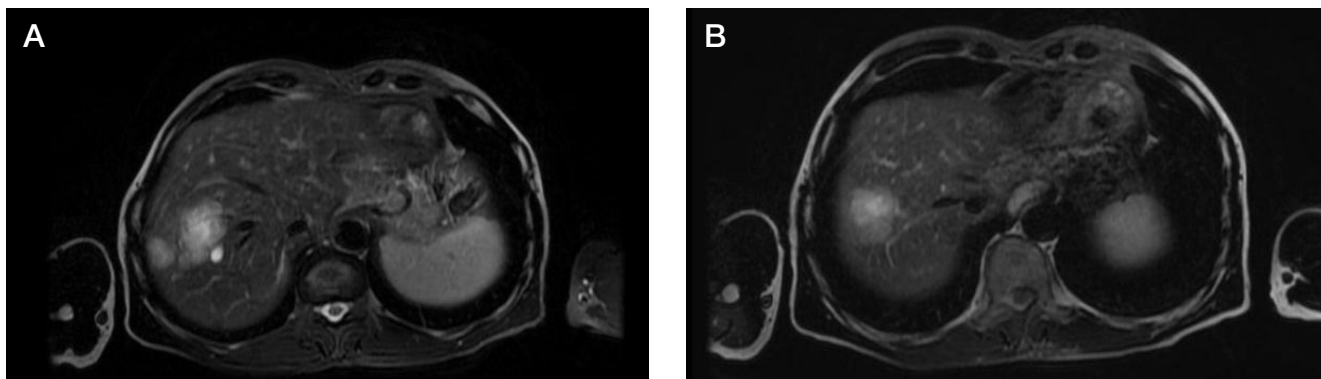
A, B. MRI scan, abdominal cavity, 18.02.2020
